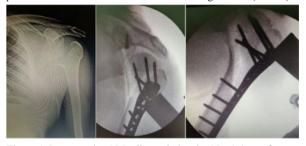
Pre-operative AP Radiograph showing Neer's 3-part fracture of right proximal humerus and Intra-operative Fluoroscopy images showing optimal fixation of fracture with PHILOS plate and screws.
